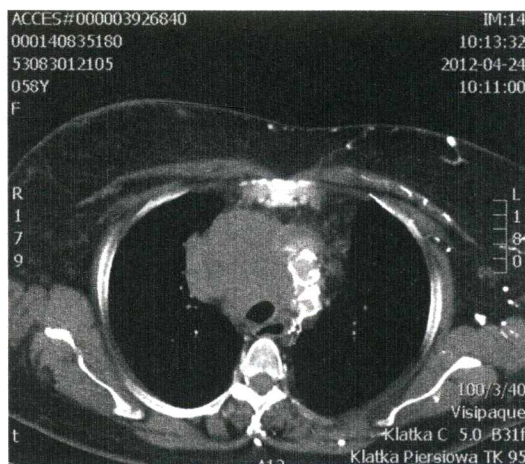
CT scan showing a large mediastinal mass, which is invading the aortic arch, compressing the right lung parenchyma, and constricting the trachea and the esophagus
